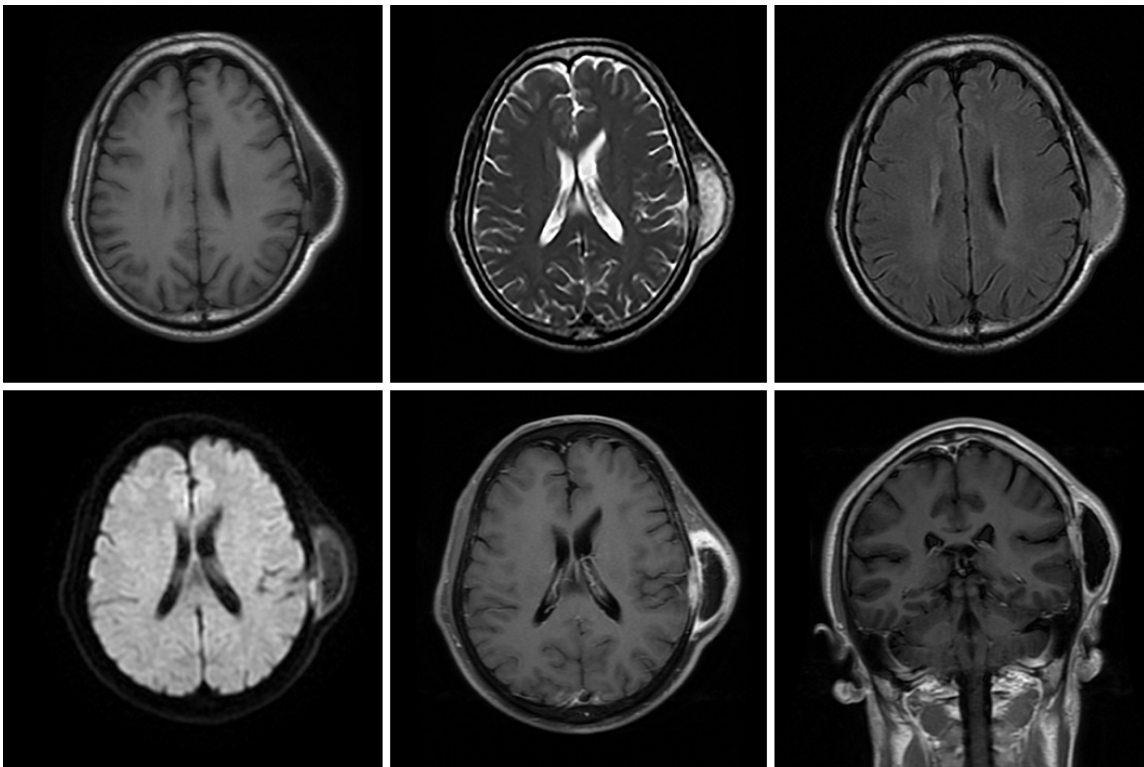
Magnetic resonance imaging shows a mass in the left temporal muscle, with obvious enhancement around the tumor, but no enhancement in the center of the tumor.
